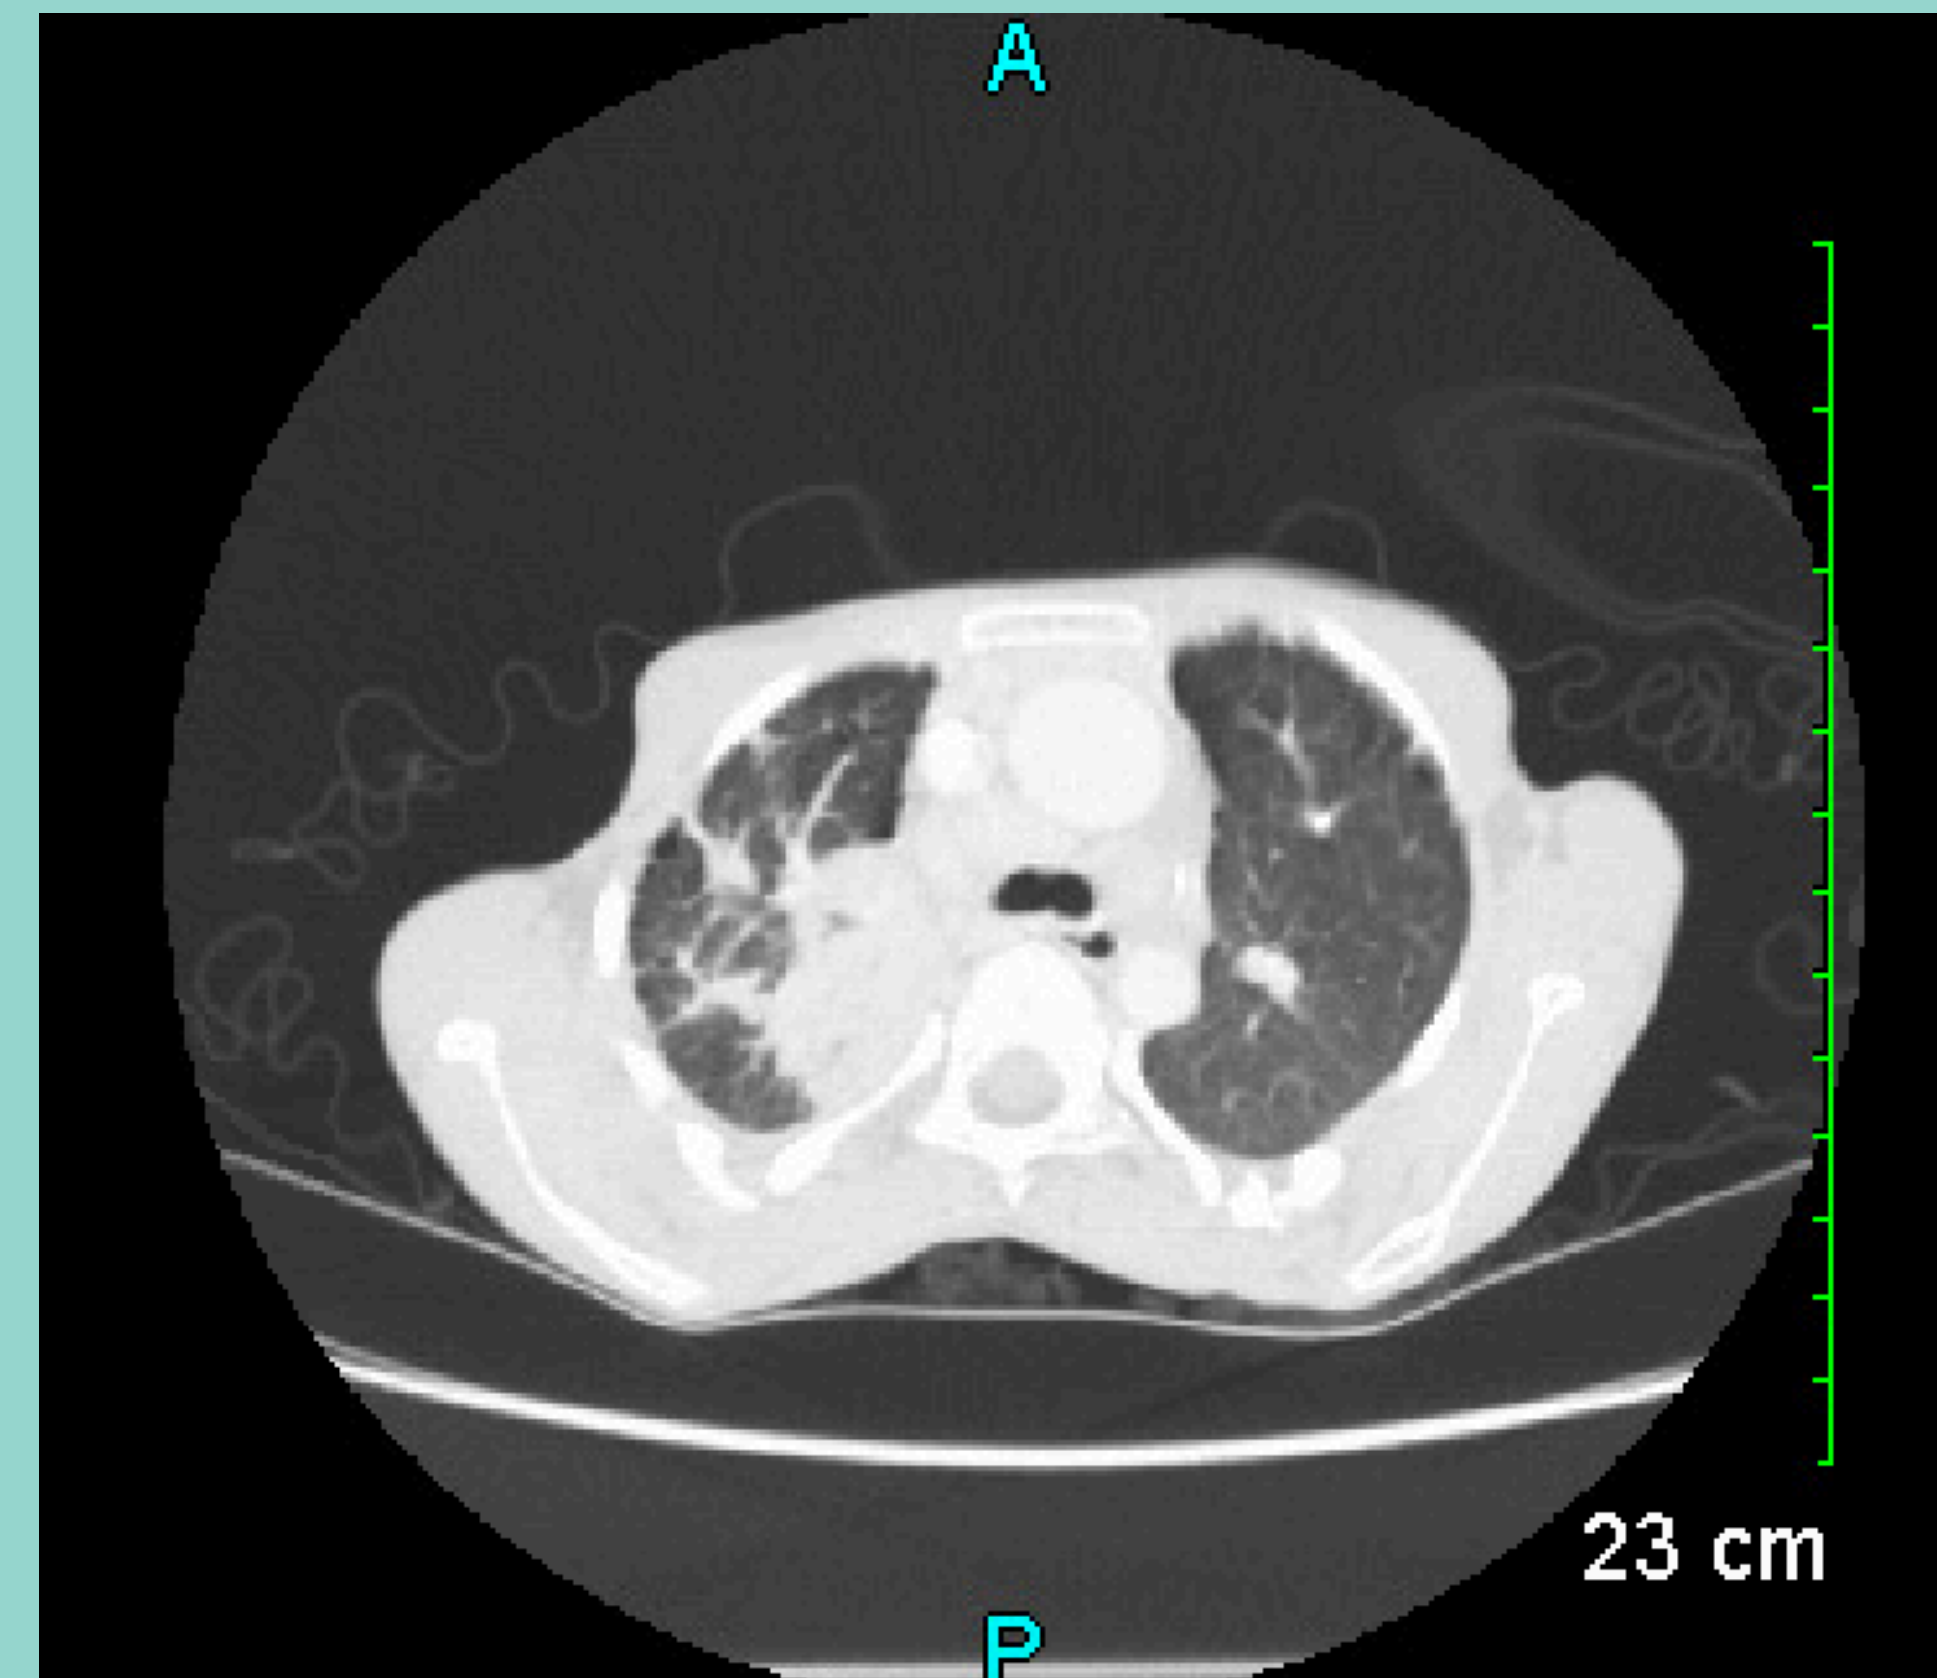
CT Chest with Contrast showing large consolidation in right upper lobe.
